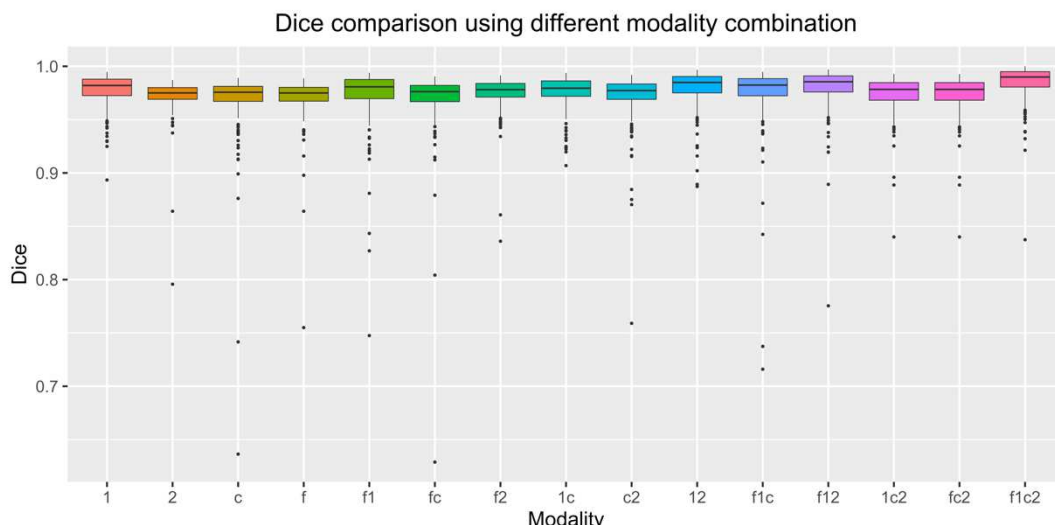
Quantitative dice comparison using different modality combination in the testing phase. In the x axis, 1, 2, c, and f represents T1, T2, T1ce, and T2-FLAIR, respectively. For an example, f1ce means that the combination has all four image sequences.
